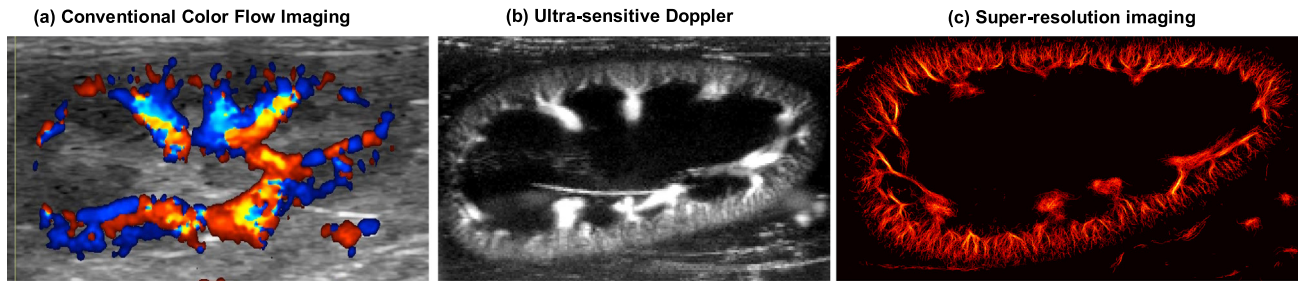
Example ultrasound blood flow images taken from a rabbit kidney. (a) Conventional color Doppler flow imaging is limited to the larger vessels, predominantly in the medullary region. (b) Ultra-sensitive Doppler, enabled by ultra-fast ultrasound imaging, reveals small vessels in the kidney cortex (reprinted from [76]). (c) Super-resolution ultrasound imaging can resolve these cortical microvessels without sacrificing penetration depth (reprinted from [77]).
